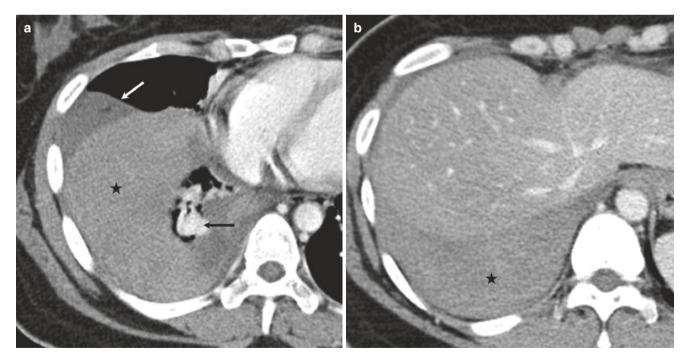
Acute hemothorax from bleeding arteriovenous malformation (AVM). (a, b) Axial CT images show dependent high-density fluid with low-density fluid (white arrow) in the upper pleural compartment and an AVM (black arrow)
